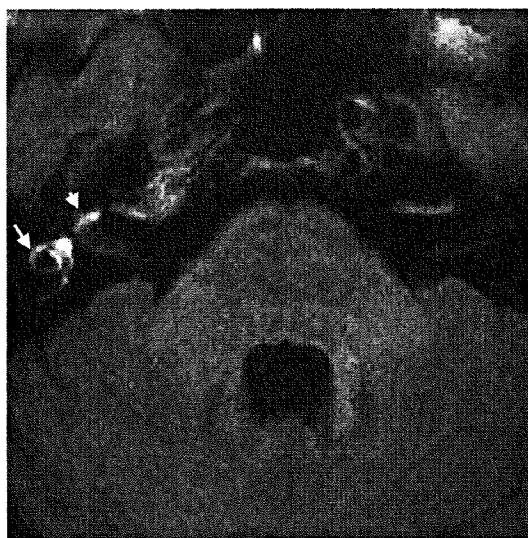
ガドリニウム造影剤を8倍に薄めて右鼓室内に投与し、1日後に撮ったMRI所見(3D-FLAIR)
